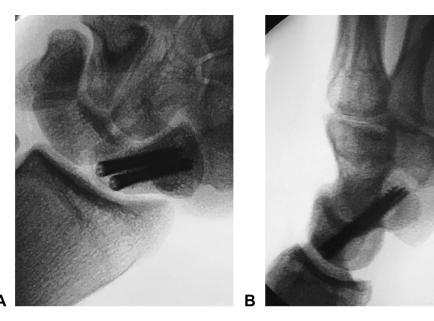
Intraoperative A posteroanterior and B lateral radiographs.
